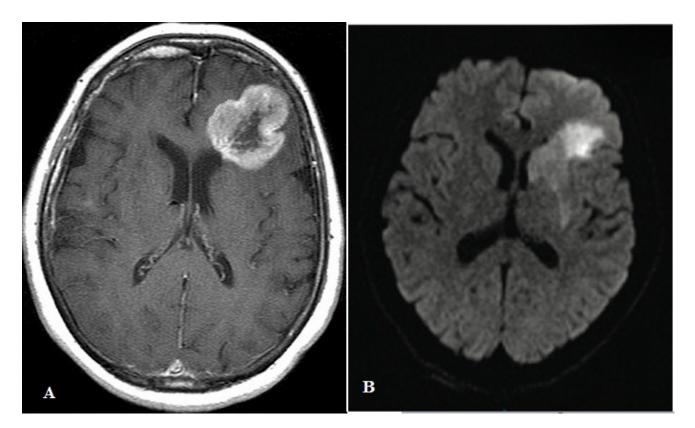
A: T1-weighted MRI shows enhanced lesion with peripheral edema on left frontal area, compatible with high grade glioma. B: Left frontal area of same patient has hyper intense signal in diffusion weighted imaging (DWI), compatible with ischemic area
